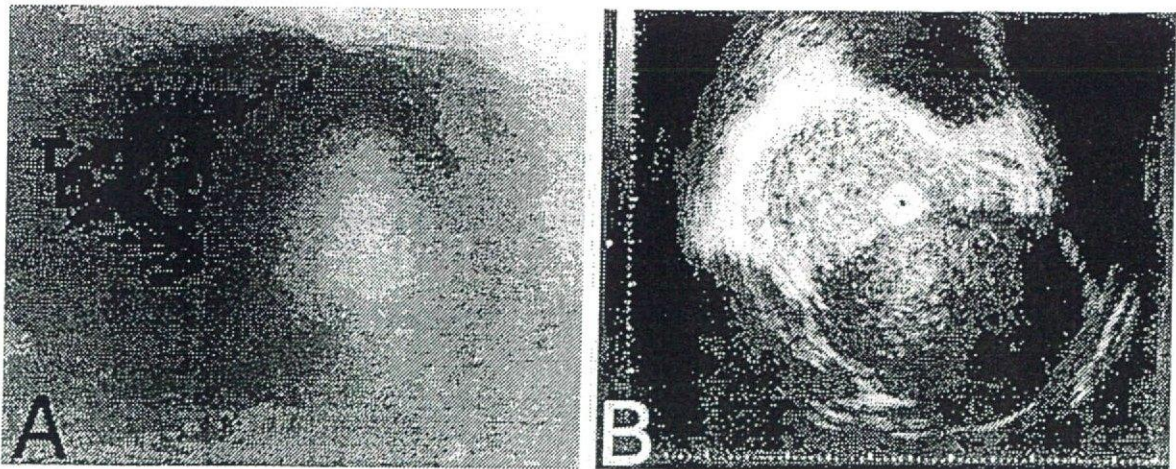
Endoscopic examination: (A) esophagoscopy shows a submucosal lesion covered with normal esophageal mucosa; (B) endoscopic ultrasonogram shows a submucosal tumor continuing with the proper muscle layer of the esophagus.
